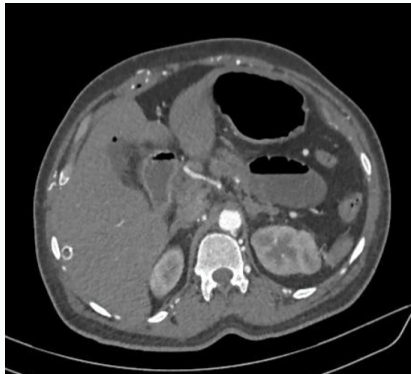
CT image showing block in the coeliac trunk.
